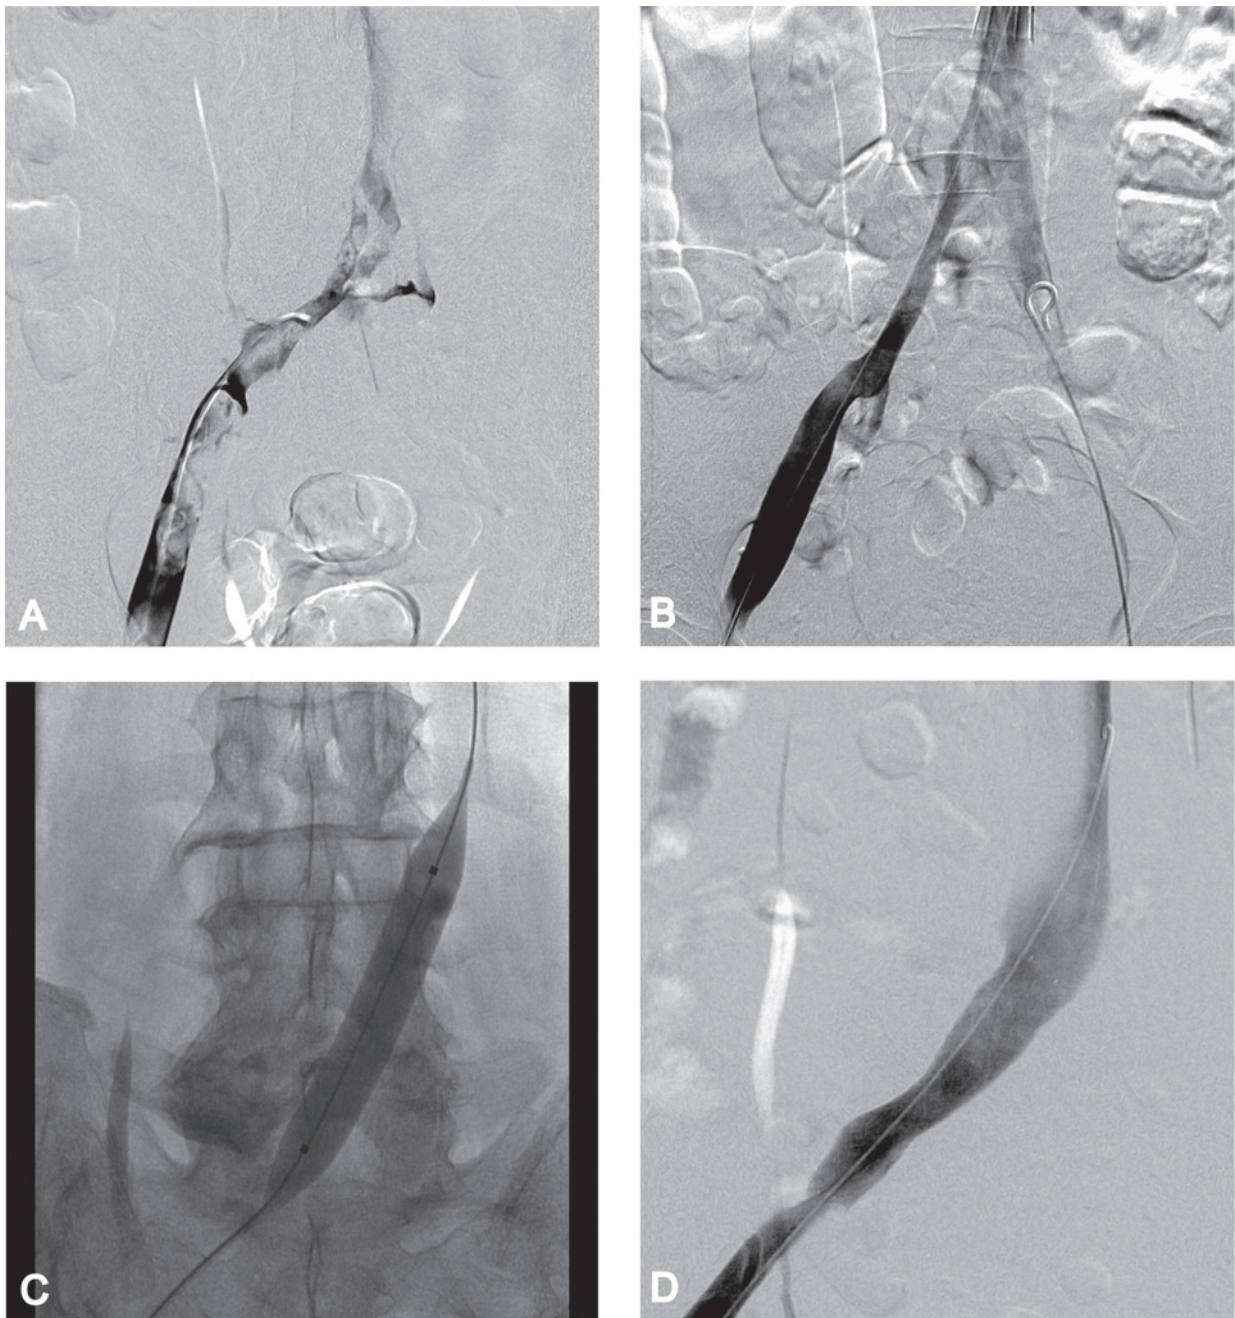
A. Initial phlebogram (prone ilio-cavagram) of a patient with extensive iliofemoral DVT who presented with a swollen, painful left leg. Using ultrasound guidance, the catheter was positioned into the thrombus of the ilio-femoral segment. A plasminogen activator (t-PA) was infused at 1 mg/hr. B. After 22 hours of catheter-directed t-PA infusion, the patient had a good phlebographic and clinical response. A stenosis of the left iliac vein was identified. C. The stenosis was treated with balloon angioplasty and a 16-mm Wallstent was deployed and dilated. D. Final phlebogram showing unobstructed venous drainage into the vena cava.
